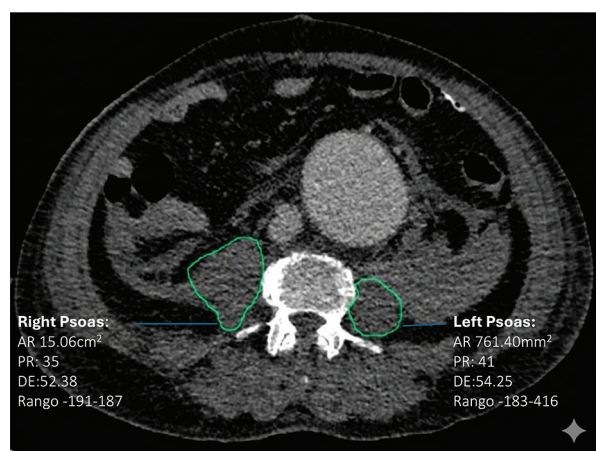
Cross-sectional view of the computed tomography with the Psoas muscle area measurement in a patient with an abdominal aortic aneurysm.
